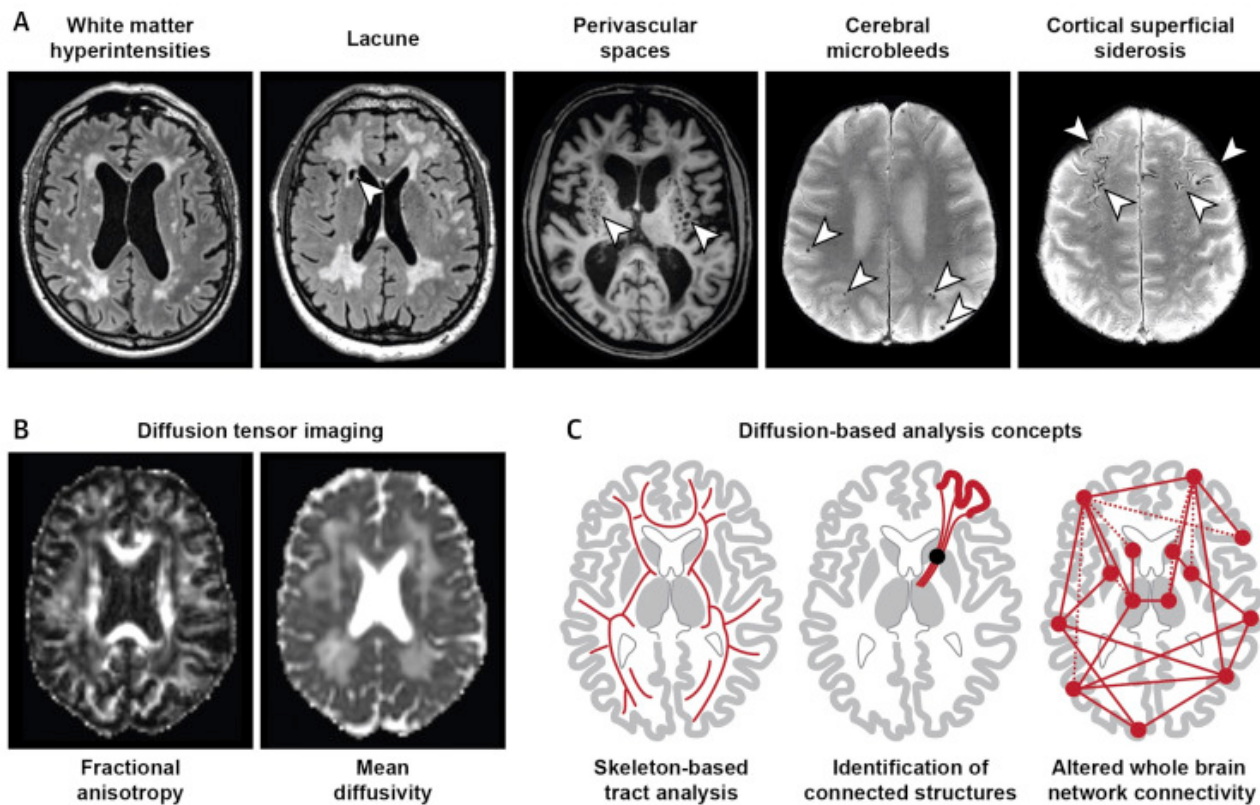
MRI correlates of cerebral small vessel disease.
